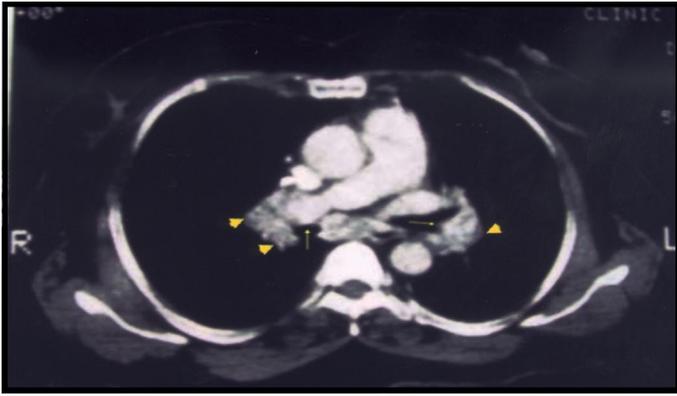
Computed tomography chest mediastinal window. Bulky hilar areas bilaterally, more marked on the right. Arrow head pointing to enlarged hilar lymph nodes. Arrows pointing to pulmonary arteries.
